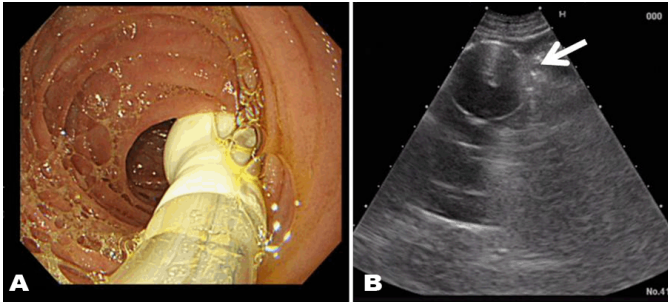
(A) A balloon of ileus tube is placed in jejunum and expanded after with watching by endoscopy; (B) A expanded balloon of ileus tube is easy to find by ultrasonography (arrow).
